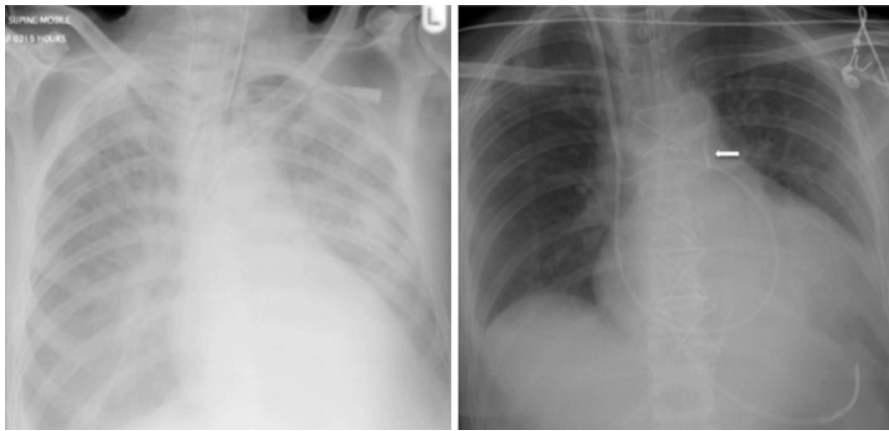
CXR from two different patients with cardiogenic shock. The *left panel* shows the CXR of a 60-year old male presenting with severe hypotension and respiratory distress requiring intubation. There is pulmonary edema as evidenced by widespread bilateral alveolar opacification and supine pleural effusions. The *right panel* shows that of a 75-year old patient who underwent treatment for shock post-cardiac surgery with good improvement in the radiographic appearances. Intra-aortic balloon pump catheter tip is projected immediately below the aortic knuckle (*block arrow*). Patient also has right jugular line, pulmonary artery flotation catheter and a nasogastric tube
